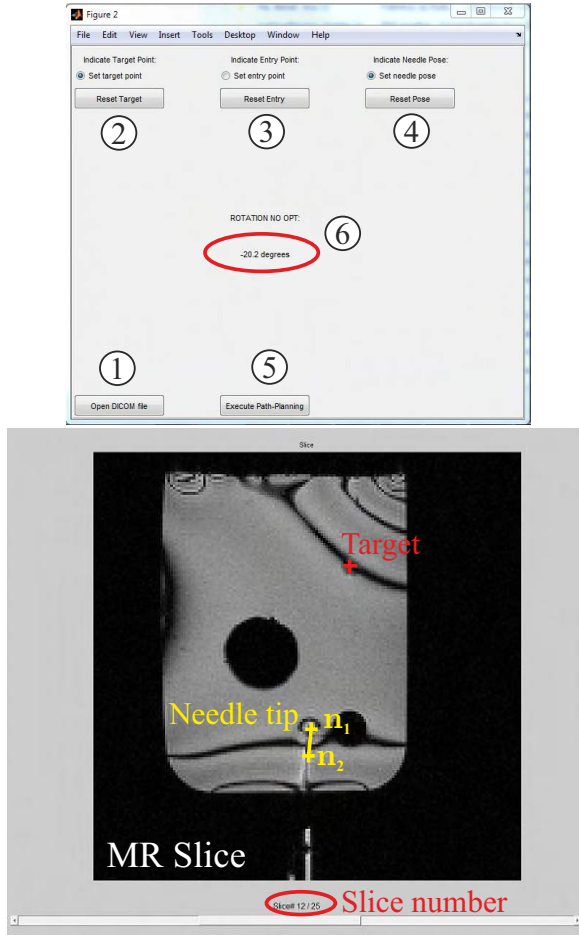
The needle tip and the target are localized using a graphical user interface (GUI). The top figure shows the GUI window and bottom figure shows the MR slice loaded by the GUI. The GUI loads the DICOM files located in a shared folder, the clinician selects the needle and the target positions by clicking on the MR image. The needle tip position is defined by two points, \mathbf{n}_1 and \mathbf{n}_2 . ① Open the DICOM data set. ② Select the target position. ③ Select the entry point. ④ Select the tip pose. ⑤ Run the steering algorithm. ⑥ Rotation angle to be applied.
